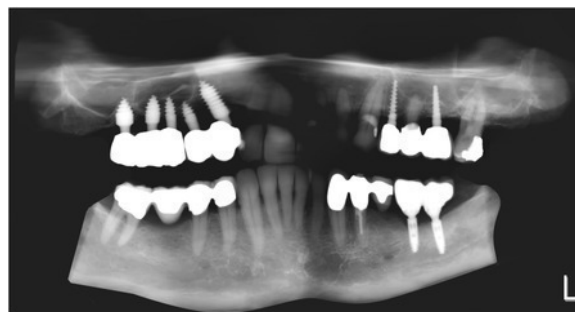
Post-mortem panoramic radiograph performed in April 2016.
